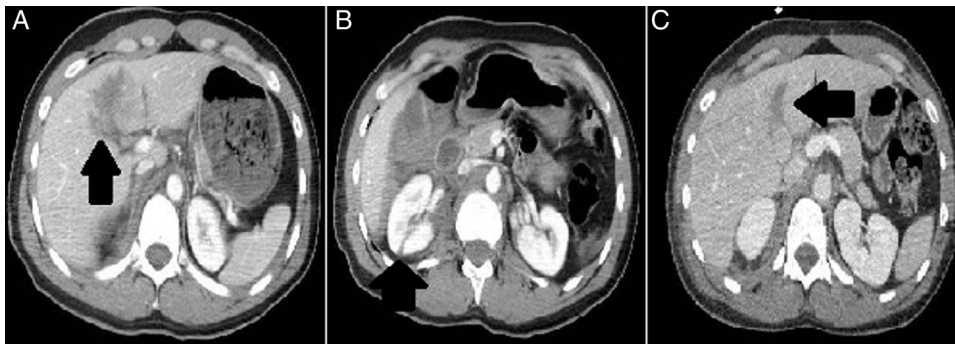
(A) The arrow shows one hypodense area in the hepatic segment V that is consistent with the hepatic lesion reported. (B) The arrow shows one right renal lesion at posterior-superior level. (C) The control CT scan conducted at day 8 confirms that the hepatic lesion has reduced its size and shape.
